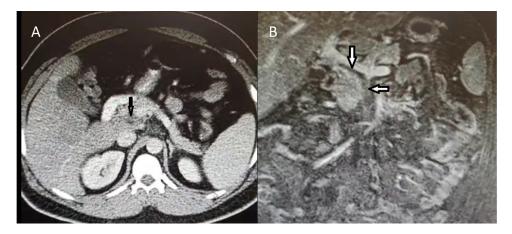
(A) Computed tomography taken on admission showed a complete filling defect of the superior mesenteric vein (Black arrow). (B) Abdominal magnetic resonance venography taken on the second day of the admission showed thrombosis in the portal and superior mesenteric veins (white arrows).
